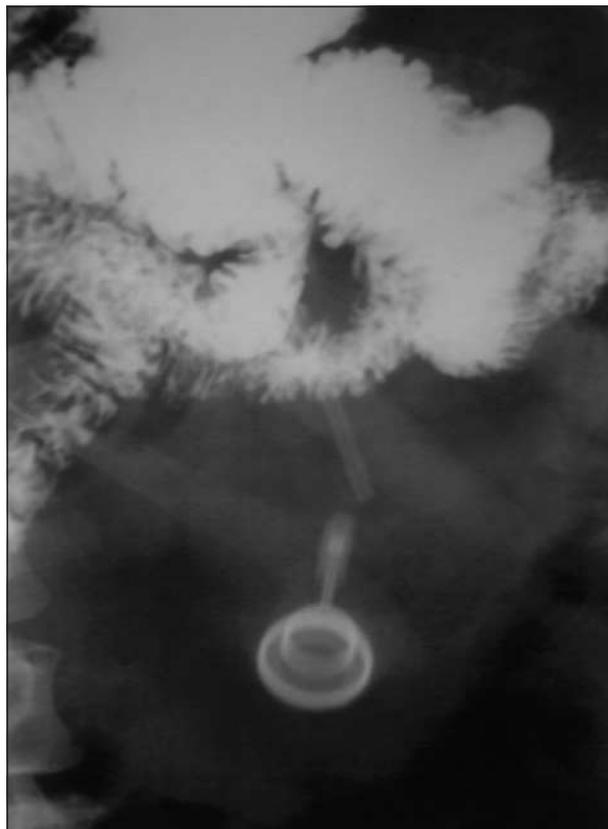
Subcutaneous tube disconnection (radiograph).
